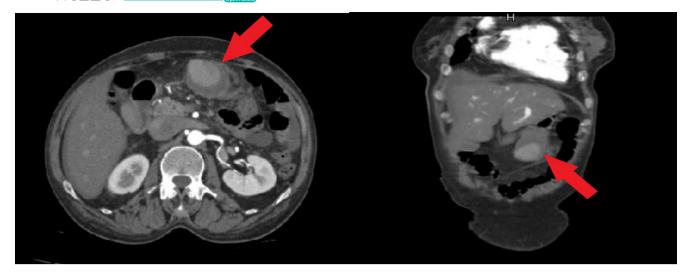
Axial and coronal images of the contrast-enhanced CT scan showing suspicious aneurysm in the epigastric area.
